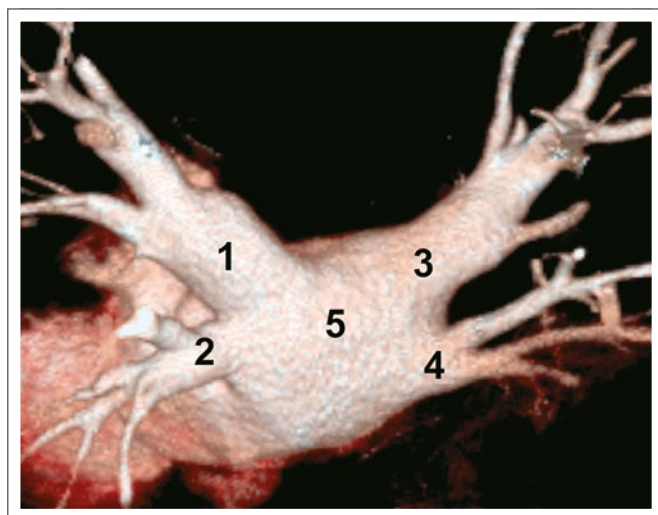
Multispiral computed tomography of left atrium and pulmonary veins (back view). 1: LUPV, 2: LLPV, 3: RUPV, 4: RLPV, 5: left atrium back wall.
